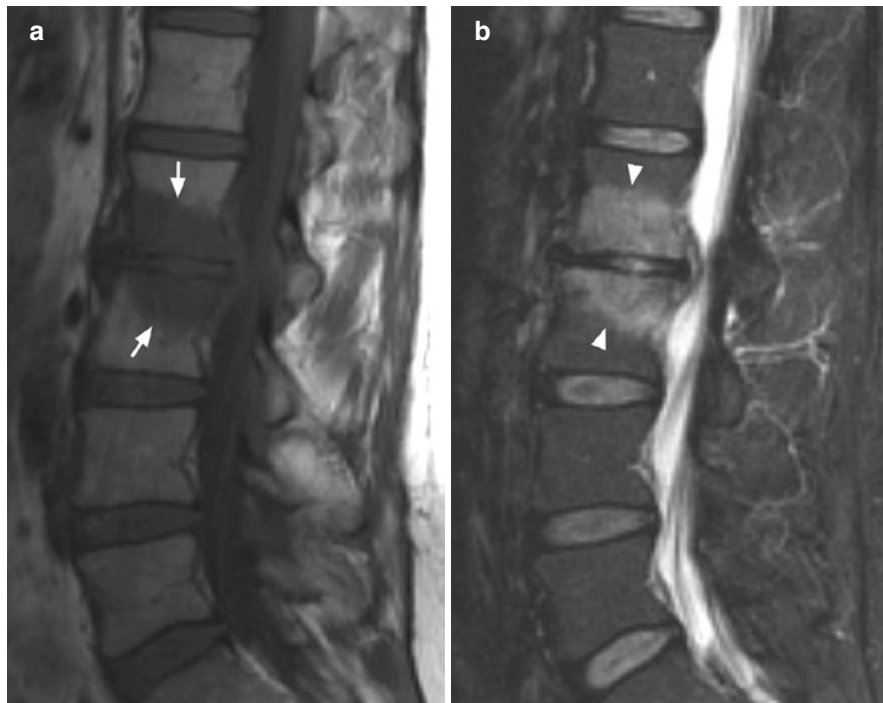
(a) Findings of spondylodiscitis on T1W MRI imaging, arrows pointing to edema in adjacent vertebral bodies as hypo-intense signal area. (b) Findings of spondylodiscitis on STIR MRI, arrowheads pointing to edema of adjacent vertebral bodies as bright signal area
